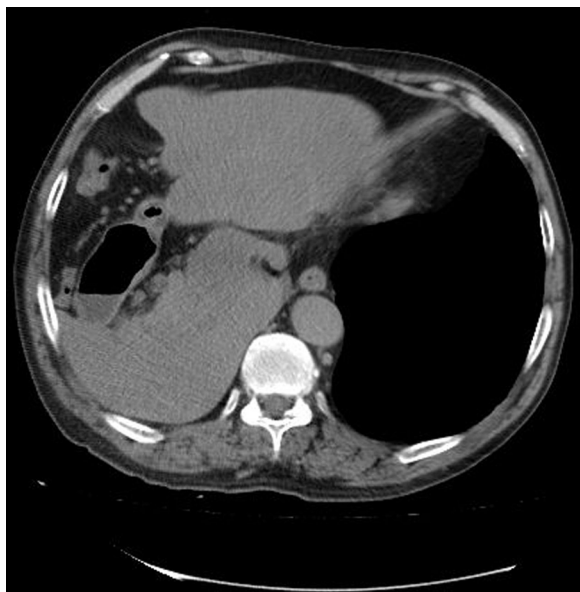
Herniation of the liver, gallbladder, omentum and stomach in thoracic CT.
